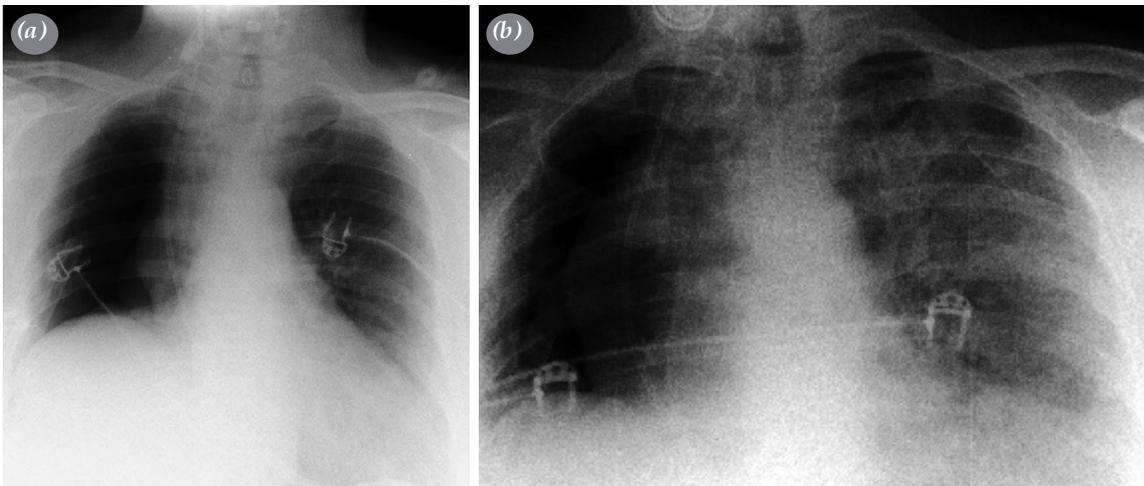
The patient who underwent right pneumonectomy due to a lung adenocarcinoma; (a) Chest radiograph taken in the early postoperative period and (b) on postoperative Day 3. Due to post-pneumonectomy pulmonary edema, the patient died on postoperative Day 3.
